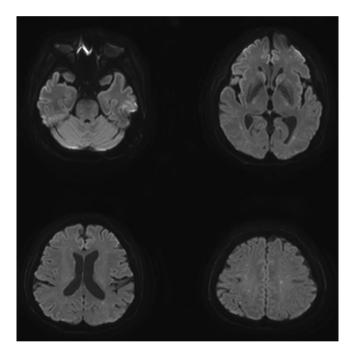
Magnetic resonance imaging 2 hours after injury demonstrating findings of tiny, multifocal, diffusion–restrictive lesions in both the cerebrum and cerebellum.
